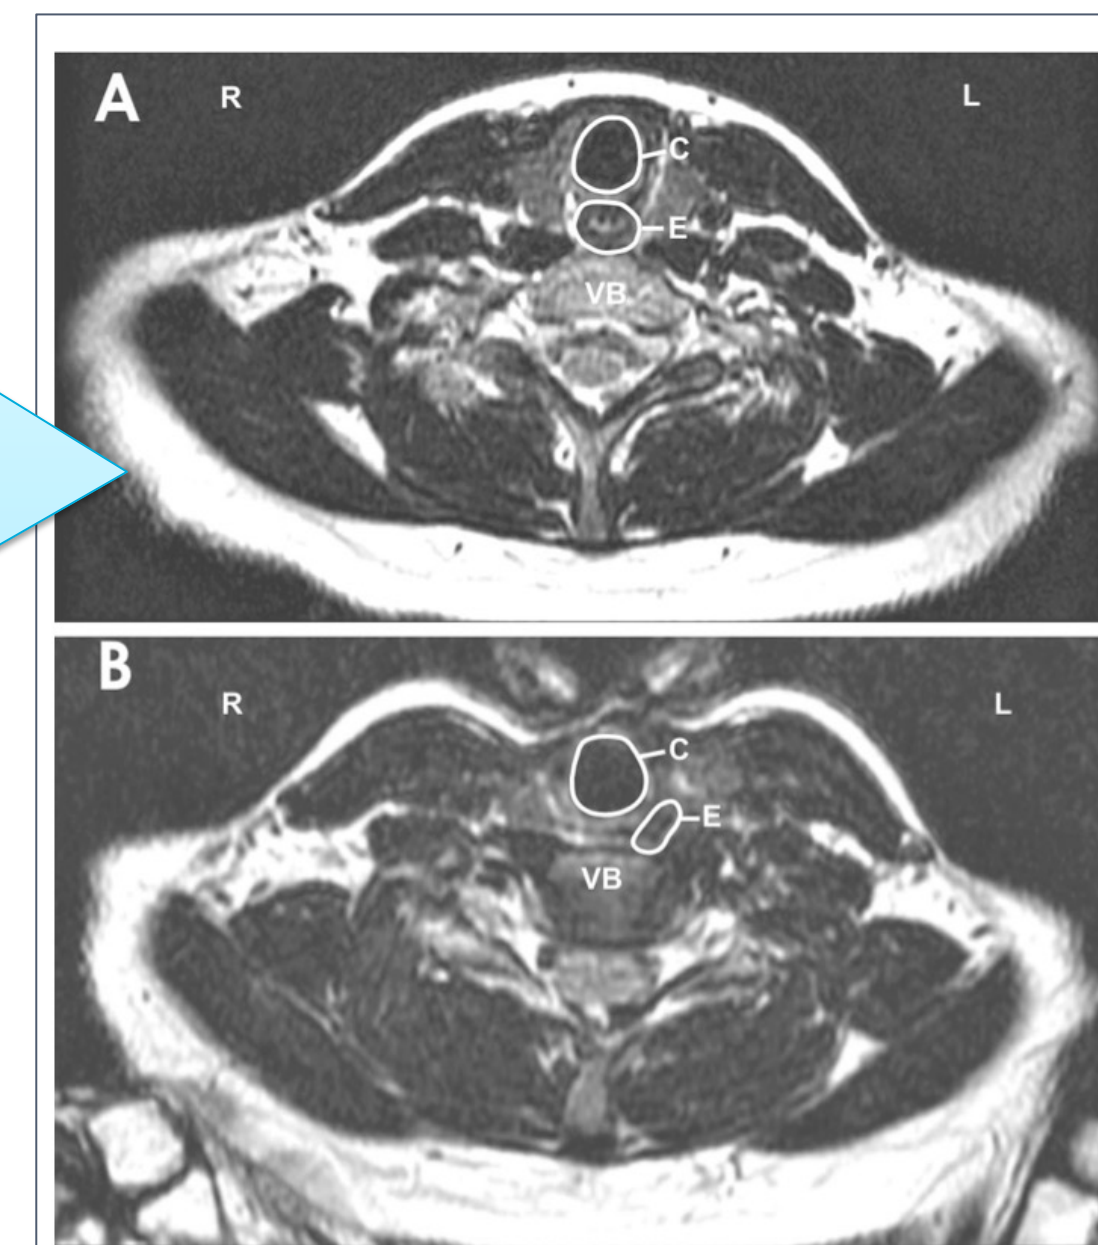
(A) Magnetic resonance image of the neck without cricoid pressure. (B) Magnetic resonance image of the same subject demonstrating 12.1 mm of lateral esophageal displacement to the left with application of cricoid pressure. C = cricoid cartilage, E = esophagus, VB = vertebral body.
